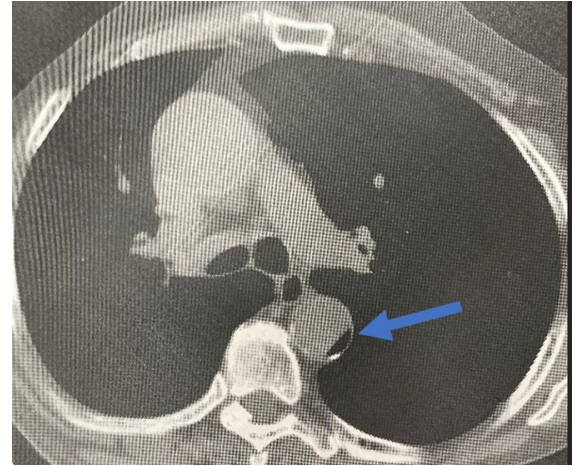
Chest CT scan showed an air embolus within the aorta (blue arrow).
